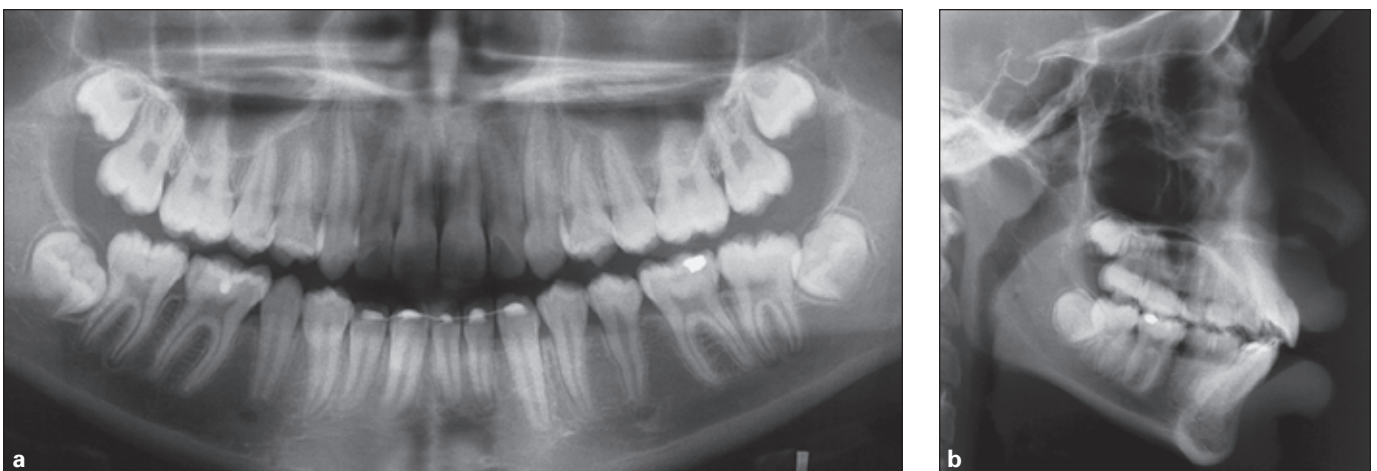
(a) Panoramic radiograph revealing good root parallelism, especially in the mandibular anterior area. (b) Cephalogram showing an almost identical situation as that at the beginning of therapy.
